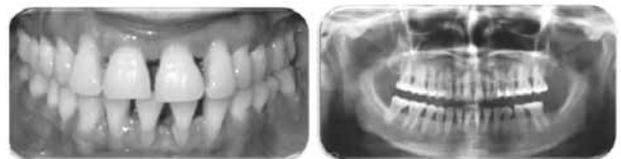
and Fig 2: Preoperative view of patient's dentition and OPG Xray
